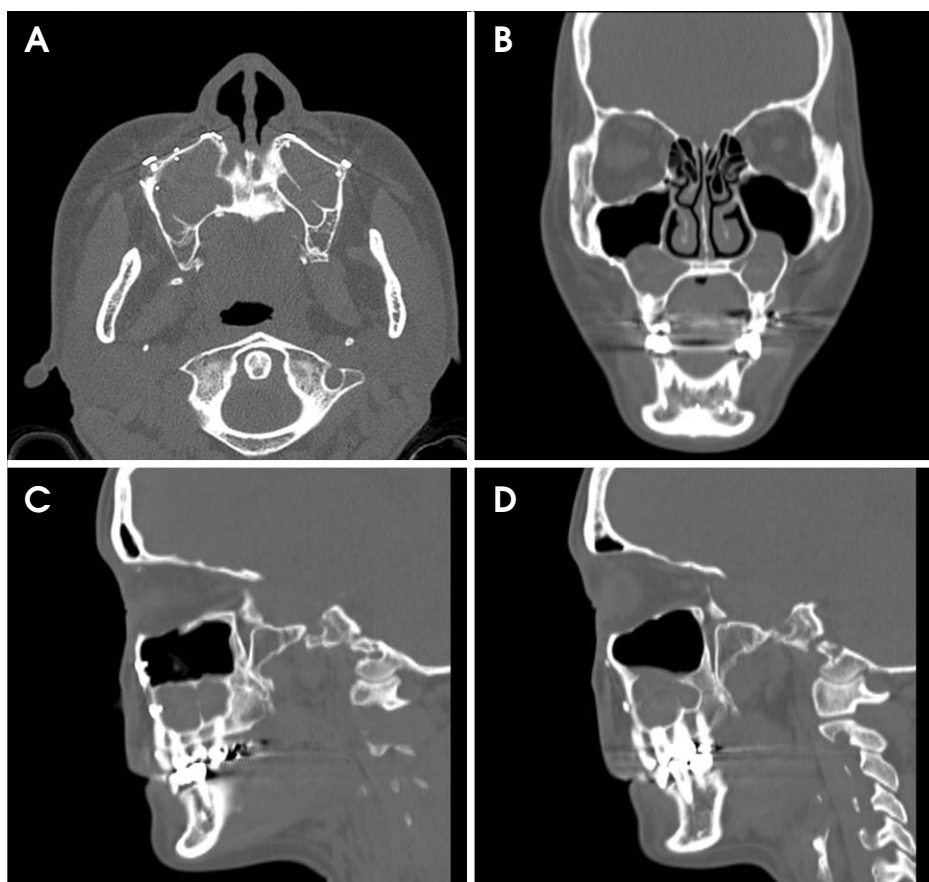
Computed tomography images show low-attenuation lesions in both maxillary sinuses. A. Axial image reveals no distinct expansion and bone destruction of the lesions. Postoperative signs such as antral wall thickening, sclerotic change, and loss of continuity of the cortical antral wall lining are not seen. B. Coronal image shows that the lesions extended slightly below the floor of both nasal sinuses. C and D. Sagittal images of right (C) and left (D) maxillary sinuses reveal the undulated margins, which were discontinuously corticated.
